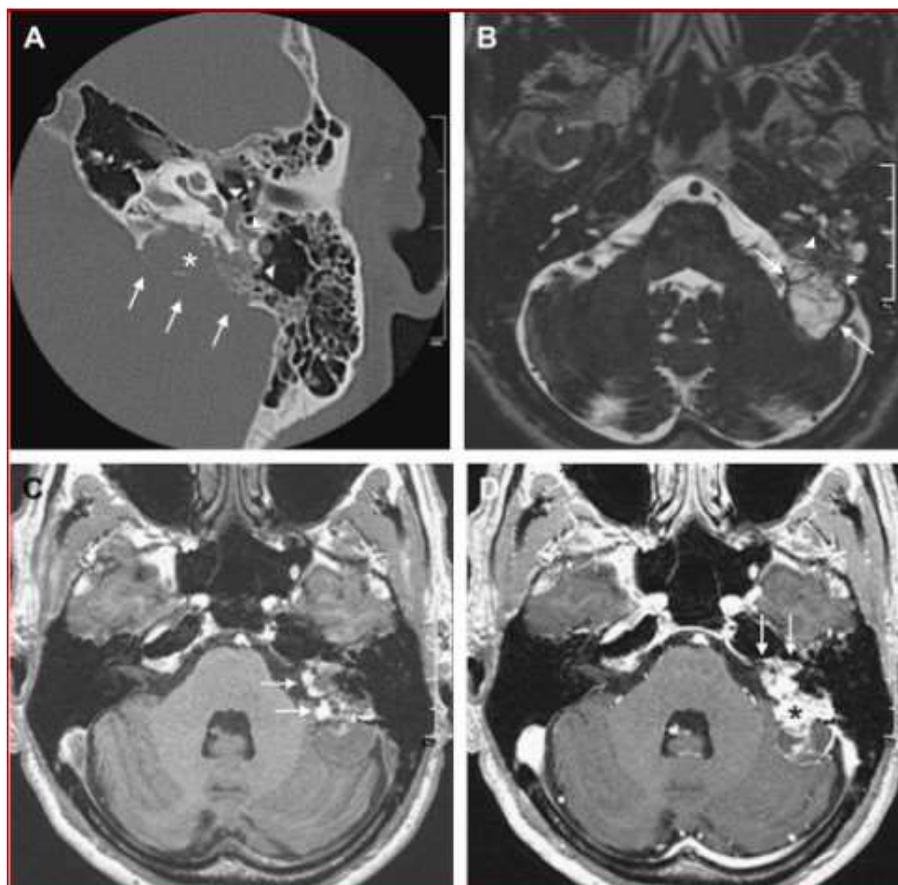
(a) The axial CT has a large mass lesion in the back of the time bone. Note that the temporal bone (arrows) has an irregular disorder. The pyramidal eminence invasion and the center ear (arrowheads) cause paralysis of the face. (b) Axial imagery of T2-weighted MR by membrane labyrinth. Large hypo-signal mass lesions characterize the rear side of the temporal bone (arrowhead). The cerebellopontine angle (arrows) forms part of the mass lesion with a hypesignal component. (c) The mass lasion in the cerebellopontine angle with typical peripheral hypersignal (arrows) is seen by T1-weighted left time-bone MR imagery. (d) The T1-weighted MR of axial postgadolinium exhibits a strong reinforcement on the backside of the left temporal bone of the mass lesion.
